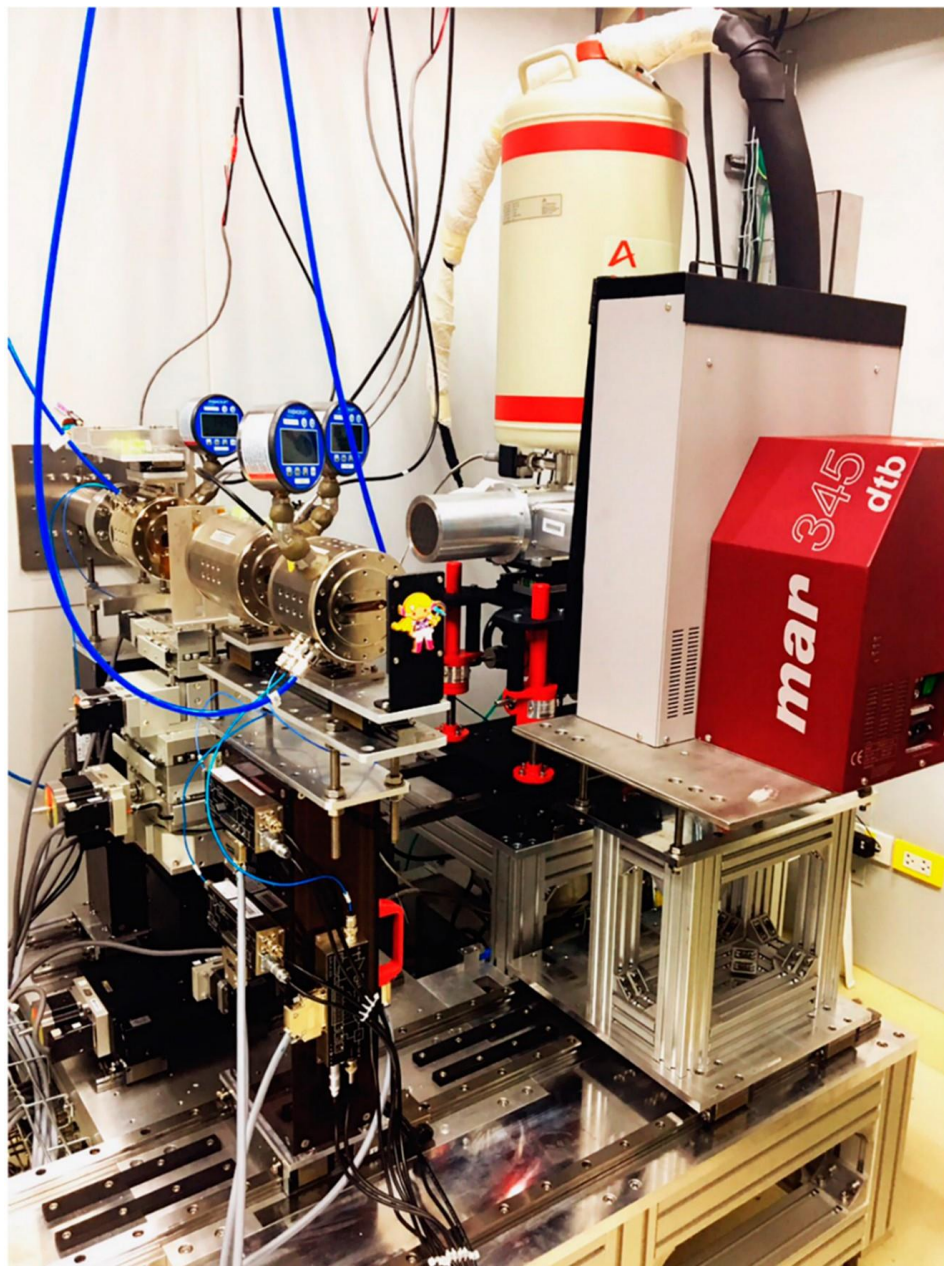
Beamline 1.1W: Multiple X-ray Technique station (Photo by C. Saiyasombat).
